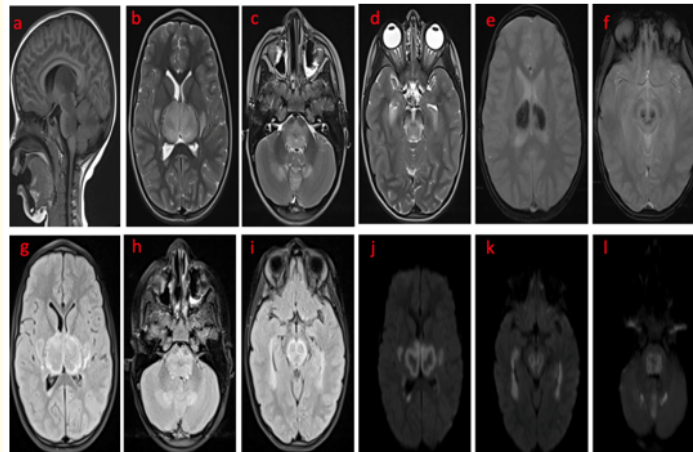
MRI sequences including sagittal T1 (a) -weighted, axial T2 (b, c, d)-weighted, FLAIR (g, h, i), diffusion-weighted imaging (j, k, l), and T2 gradient-echo images (e, f) showing bilateral and symmetric signal abnormalities involving both thalami, which appear swollen, the lenticular nuclei, the mesencephalon, the pons, and the middle cerebellar peduncles, as well as the periventricular frontal, temporal, and occipital white matter. These lesions are isointense on T1-weighted images, hyperintense on T2-weighted and FLAIR images, show diffusion restriction, and contain hemorrhagic foci appearing as signal voids on susceptibility-weighted sequences.
